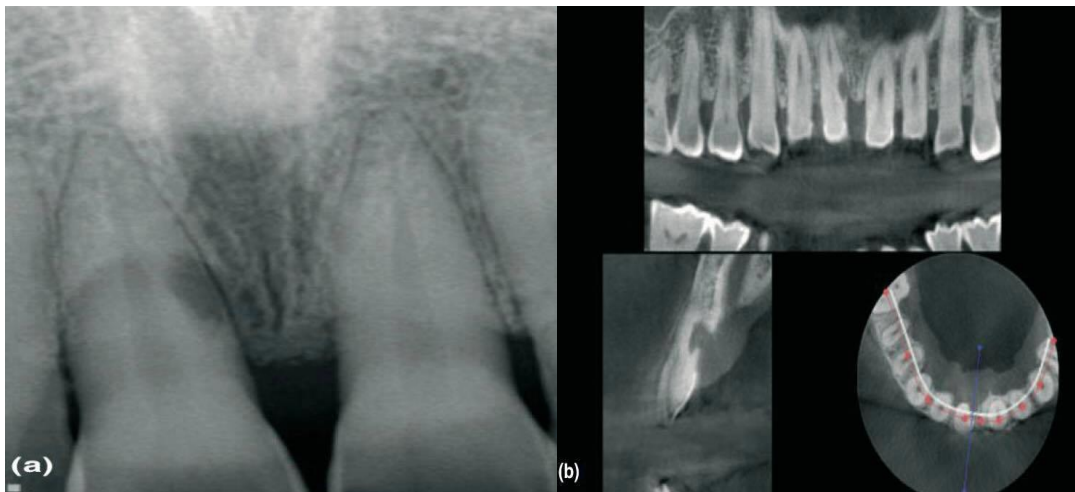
Periapical radiograph showing external root resorption (a). The CBCT of the tooth in question showed the exact location and extent of the lesion and guided the treatment plan (b).
